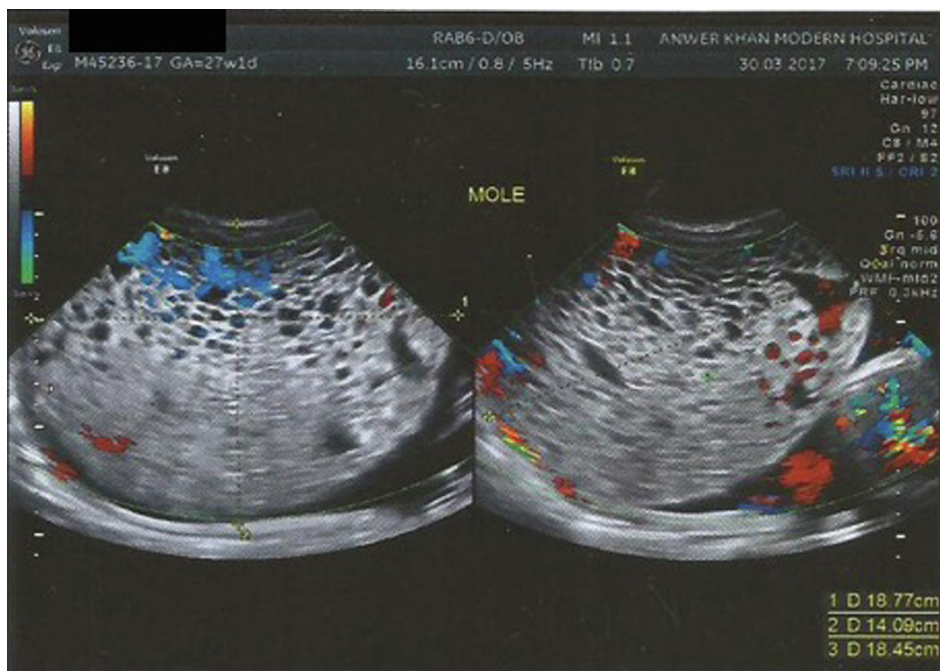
Ultrasound findings at 32 weeks gestation demonstrating characteristic vesicular "snowstorm" pattern of molar tissue.
